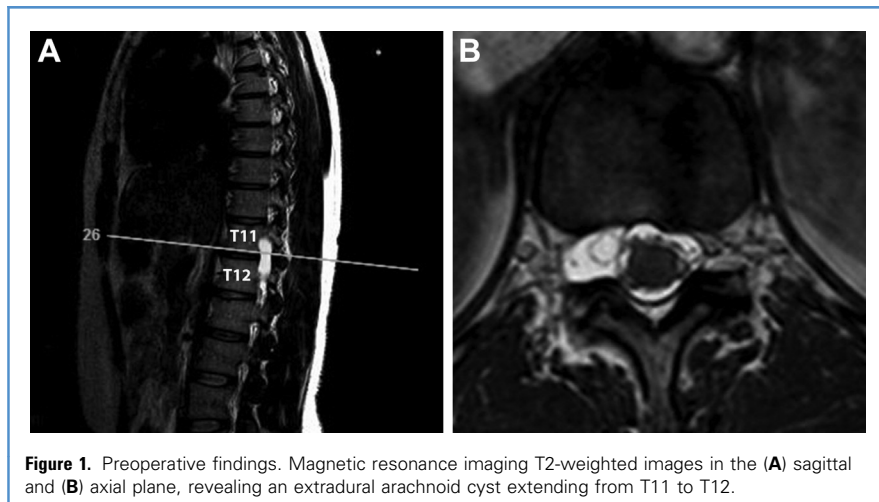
Preoperative findings. Magnetic resonance imaging T2-weighted images in the (A) sagittal and (B) axial plane, revealing an extradural arachnoid cyst extending from T11 to T12.
